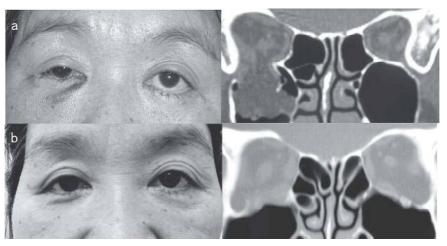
A 56-year-old woman was pushed to the floor by her husband who applied pressure to her right eye region with his left palm. She complained of enophthalmos of the right eye after the attack. A CT scan revealed a right orbital floor fracture extending from the anterior portion to the most posterior portion of the floor (a). An operation was undertaken 3 days after injury. The patient's enophthalmos resolved after the intervention (b).
